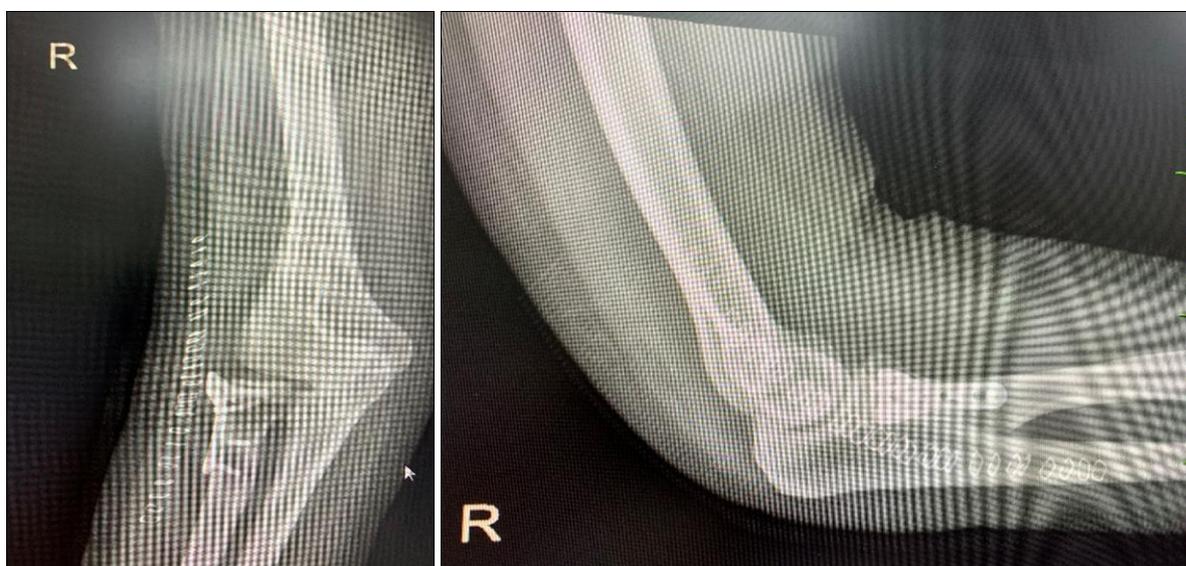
The radiographic post-operative
